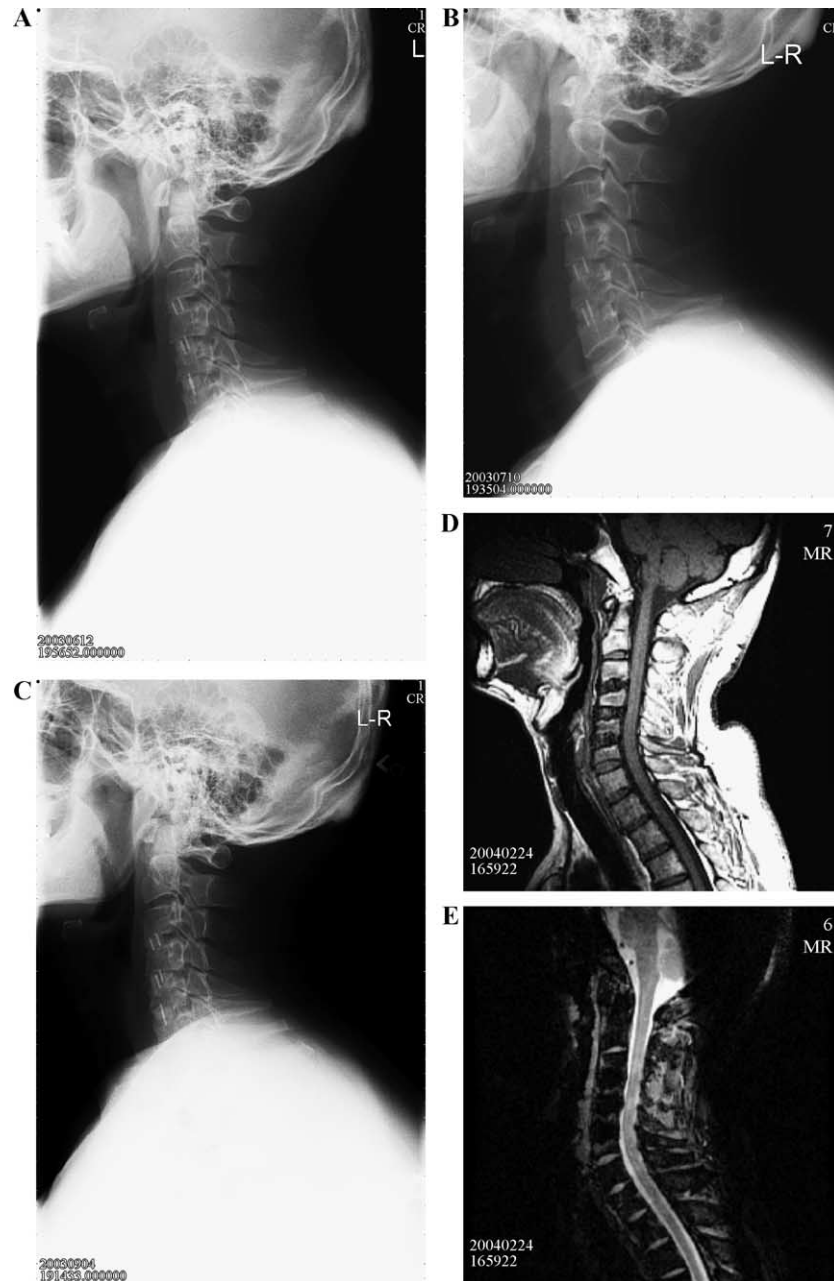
A: A 45-year-old male patient with cervical spondylosis in C3-C6 at 2 months postoperative. B: Bony fusion on C3-C4 and C4-C5 at 3 months postoperative. C: Complete three-level fusion at 5 months postoperative. D: Magnetic resonance imaging T1WI showed high intensity of bone marrow in cages. E: Magnetic resonance imaging T2WI showed low intensity of bone marrow in cages.
